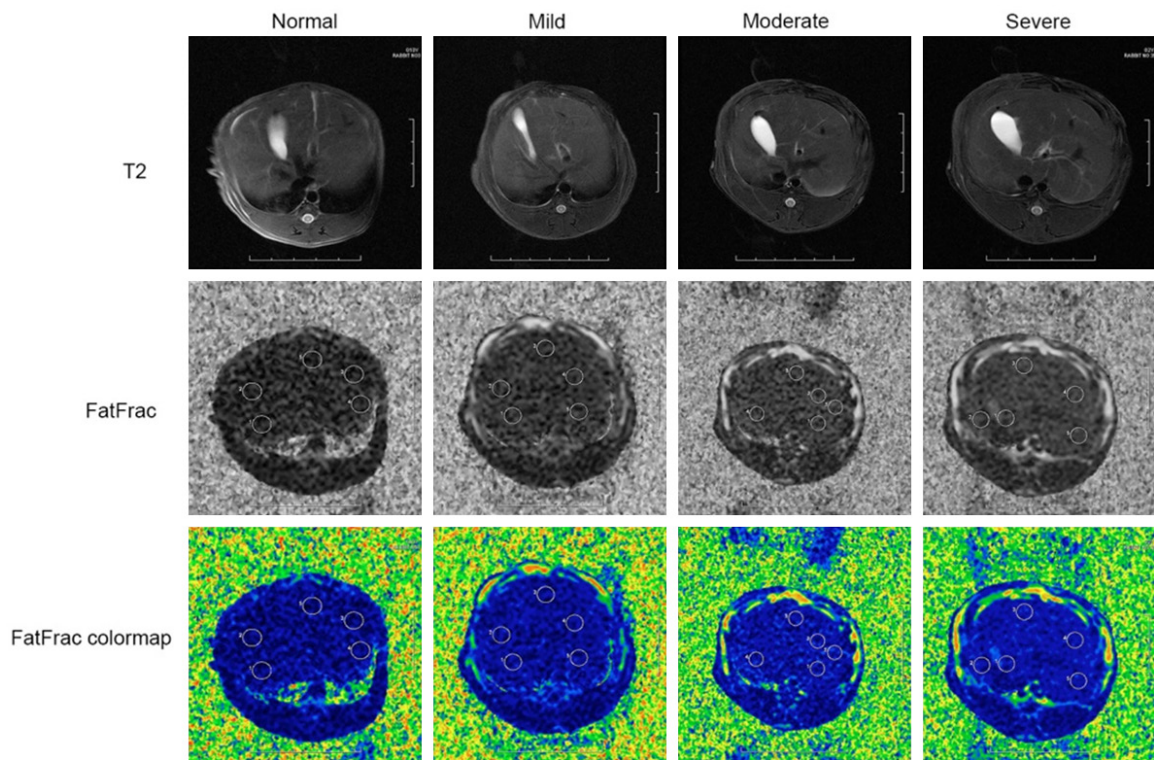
Representative T2 weighted, fat fraction and color map images in normal and HS livers. Five elliptical region of interests (ROIs) of 0.5 cm² were placed on the fat fraction and R2* images to measure MRI-PDFF and R2* values.
